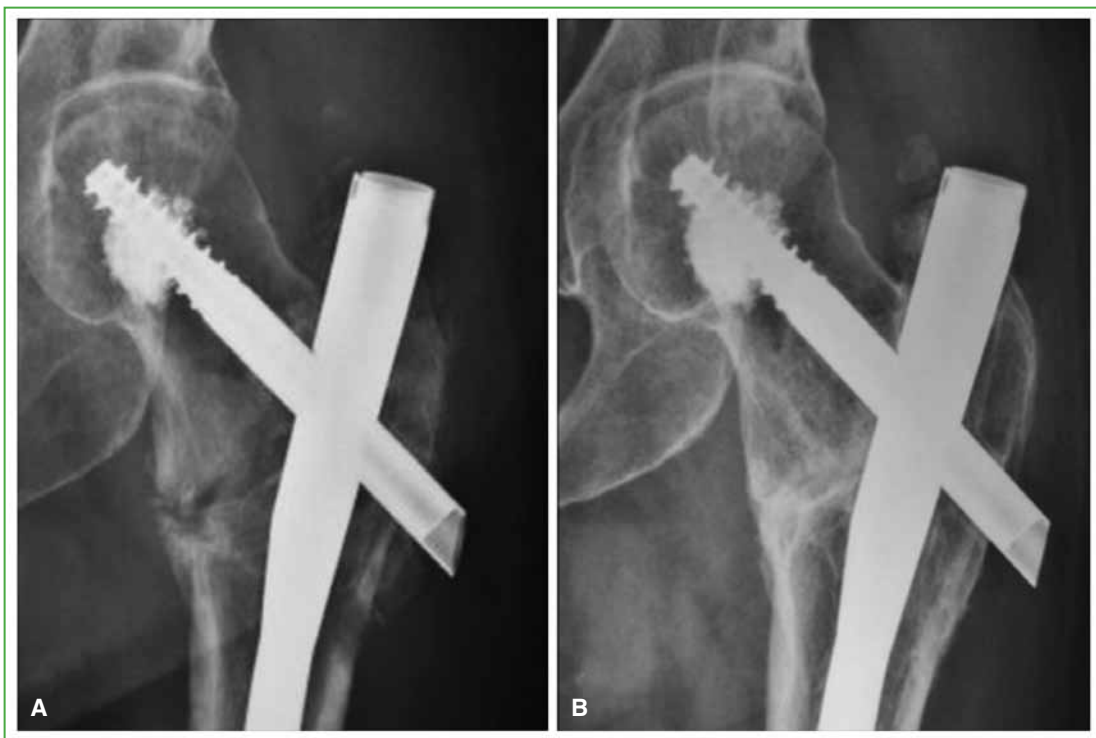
Plain radiographs of the hip, AP view. A. Revision surgery of a hip intertrochanteric fracture of one year of evolution, with no signs of consolidation. B. Results 5 months after the application of a focused shockwave treatment plan. The symptomatology disappeared. With permission from the Journal of Regenerative Science.
